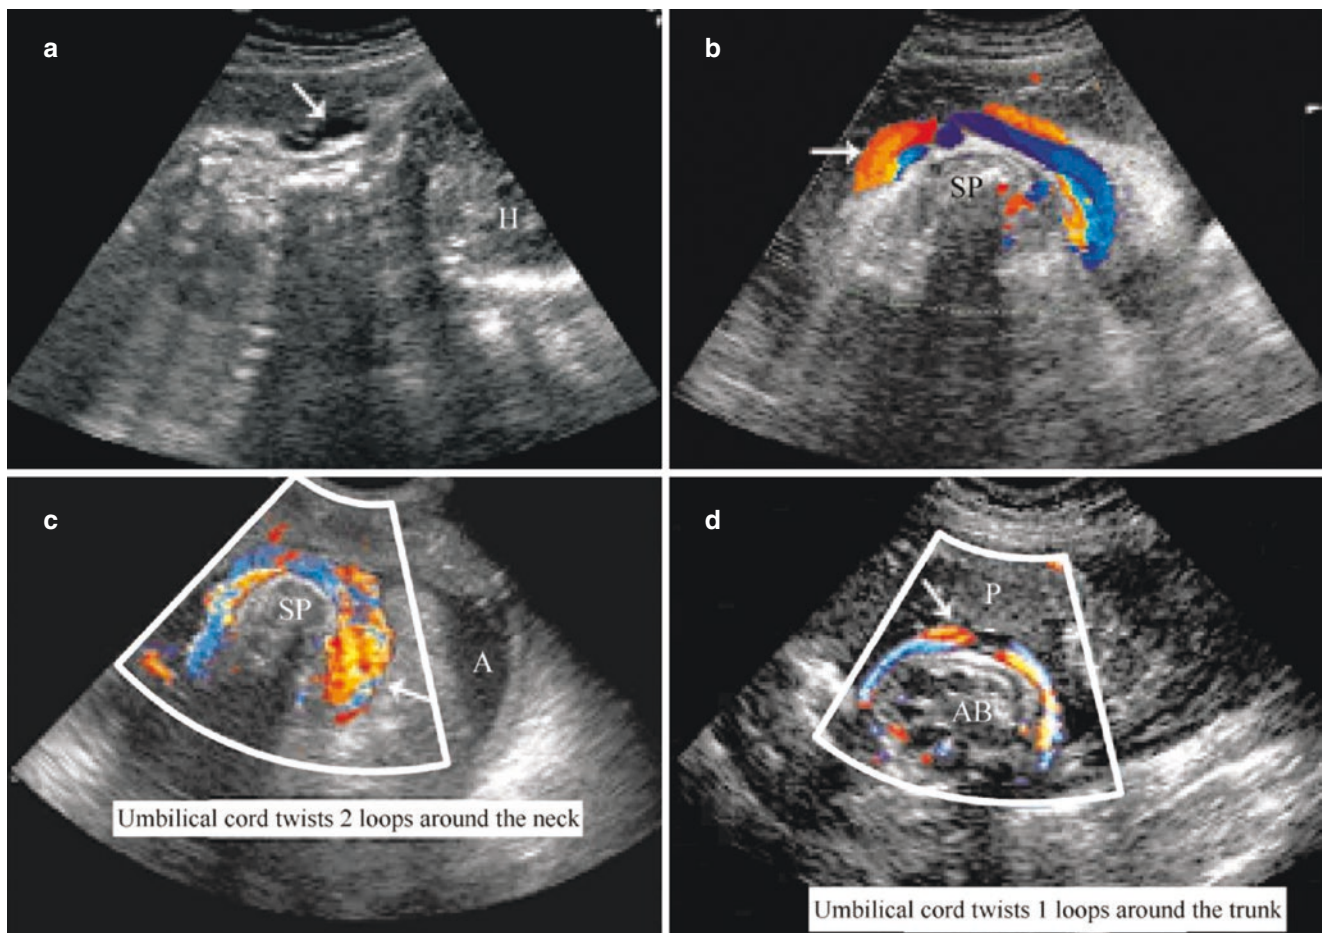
The umbilical cord twists around the neck and trunk. a. There is a “W” shape impression on the neck of the fetus in a 2-D ultrasound image. b,c. CDFI shows the umbilical cord twists 1 and 2 loops. d. Umbilical cord twists one loop around the fetal body
